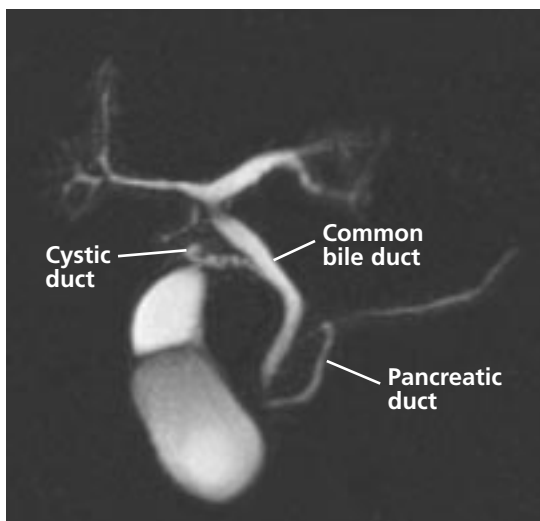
Magnetic resonance image of the normal anatomy. This technique provides anatomic detail similar to that of ERCP, but does it noninvasively.
